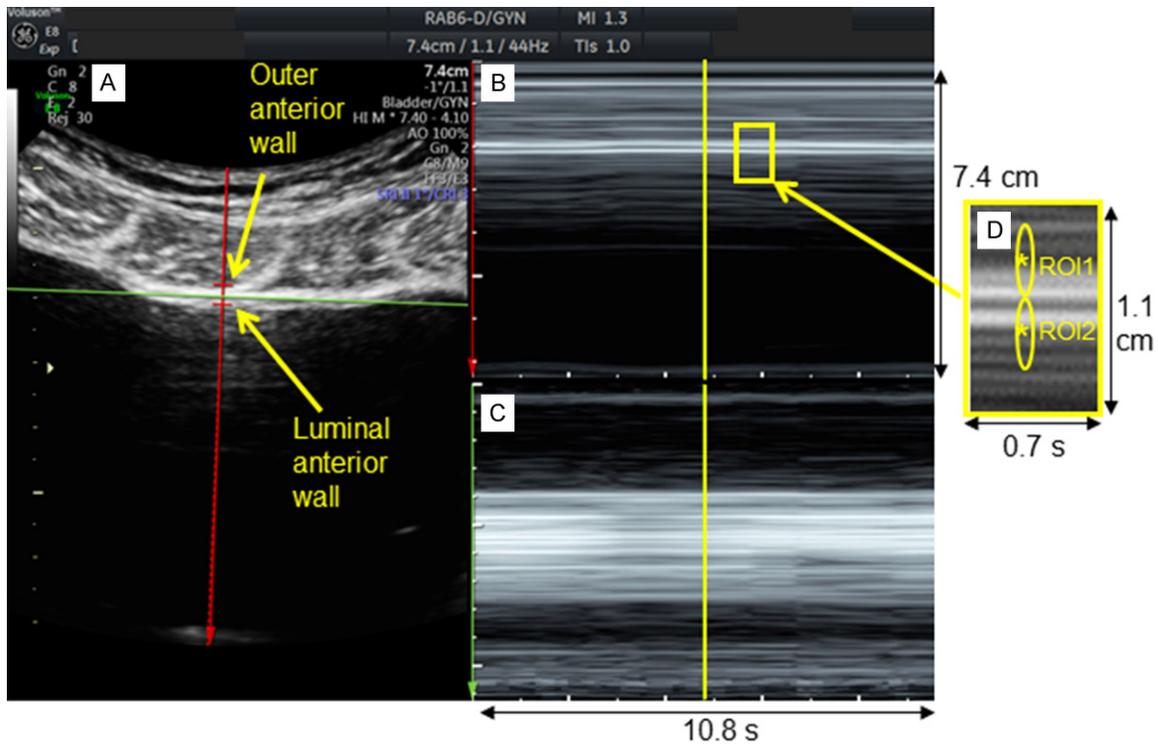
(A) The initial frame of an anatomical M-mode ultrasound cine-loop showing a 2D image of the bladder with red (perpendicular) and green (parallel) 1D lines tracked over time. Labels indicate the outer and luminal anterior bladder walls. (B) Tracking of the 1D red line over time during acquisition of 10.8 s of the 85 s cine loop. (C) Tracking of the 1D green line over time. (D) Zoomed view of the anterior bladder wall from (B) showing the locations of tracked regions of interest (ROI) with center points highlighted with asterisks on the outer (ROI1) and luminal (ROI2) edges of the bladder wall.
